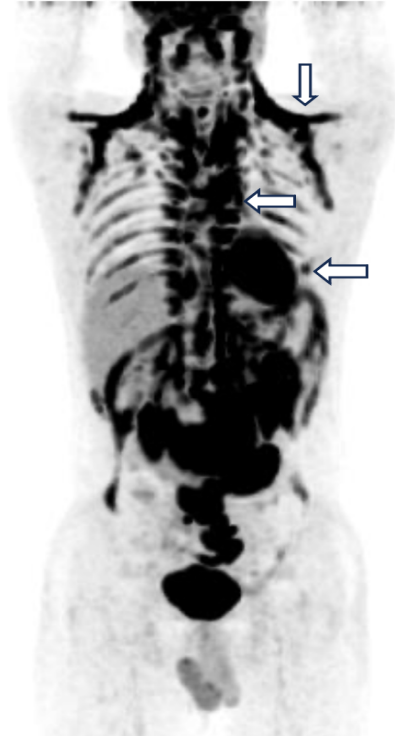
MIP image of BAT: A 30-year-old patient with metastatic gastro-pancreatic neuroendocrine tumor demonstrating multiple FDG-avid BAT deposits in the paraspinal, supraclavicular, and anterior chest wall regions (white arrows).
